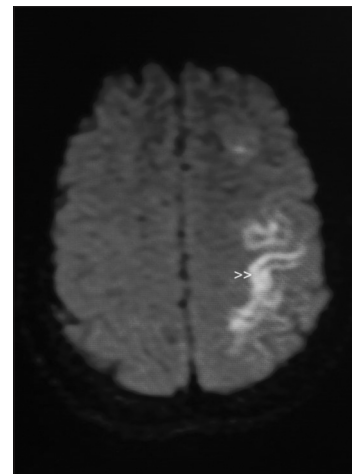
Magnetic resonance imaging showing acute infarct in the left fronto-parietal and occipital lobe
